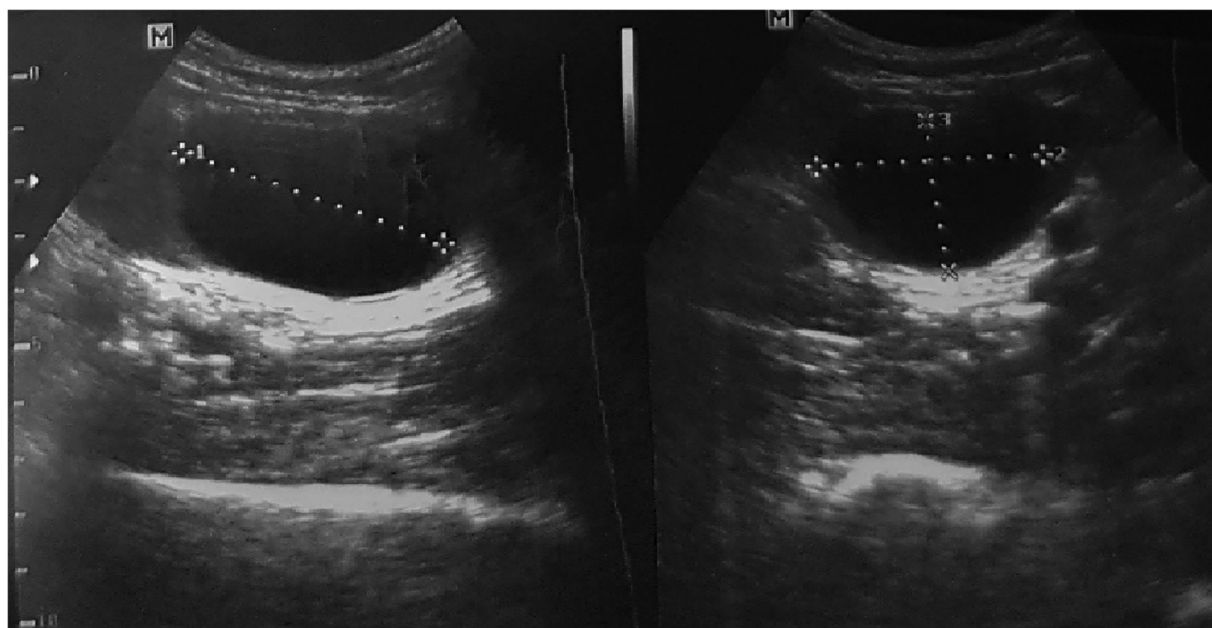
Ultrasound picture show cystic mass deep intramuscular.
